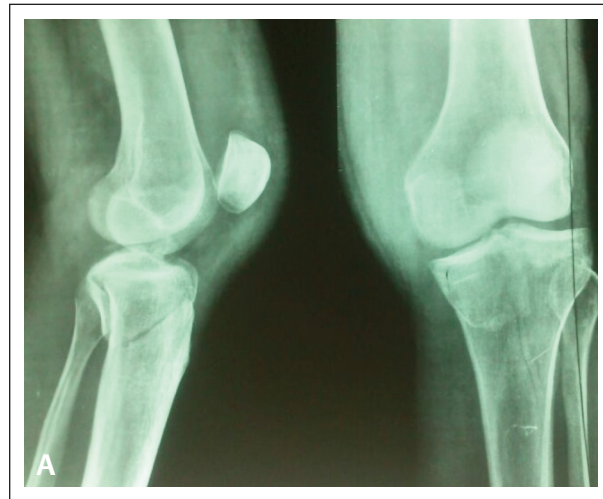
(A–C) X-rays of posteromedial shearing medial tibial plateau treated by open reduction, elevation, lag screw fixation, and posterior buttress plating.
